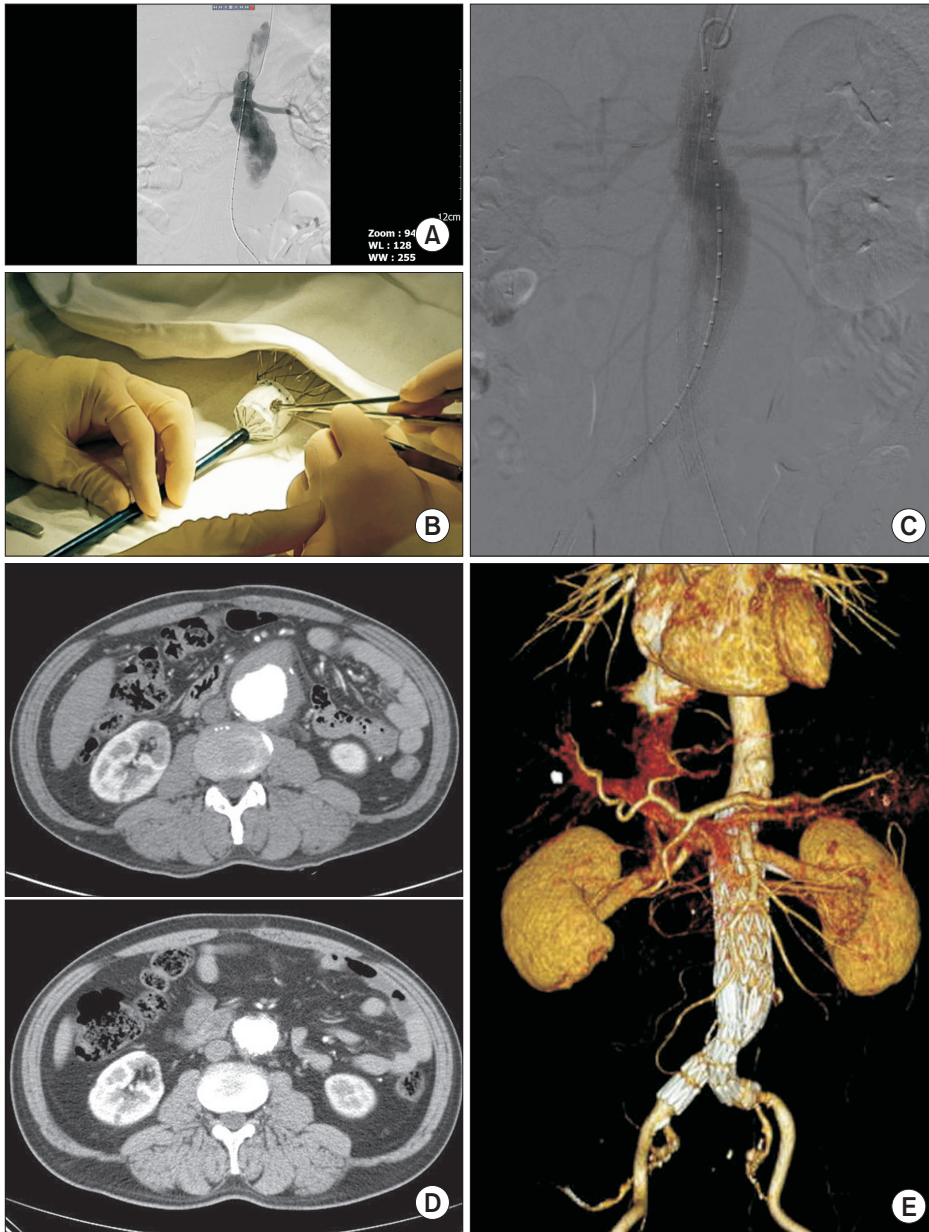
(A) A case of physician-modified endovascular stent graft for a patient with a 73.0-mm impending rupture abdominal aortic aneurysm with a short neck. The distance between the right renal artery (RRA) and left renal artery was 15 mm. (B) A single left renal fenestration was created. (C) Final angiogram showed patent flow through both renal arteries without endoleak. (D) Comparison of preoperative and postoperative CT scans (77.4 months after operation) shows complete resolution of the aneurysmal sac. (E) Follow-up CT reconstruction demonstrates patent endograft with flow through RRA.
